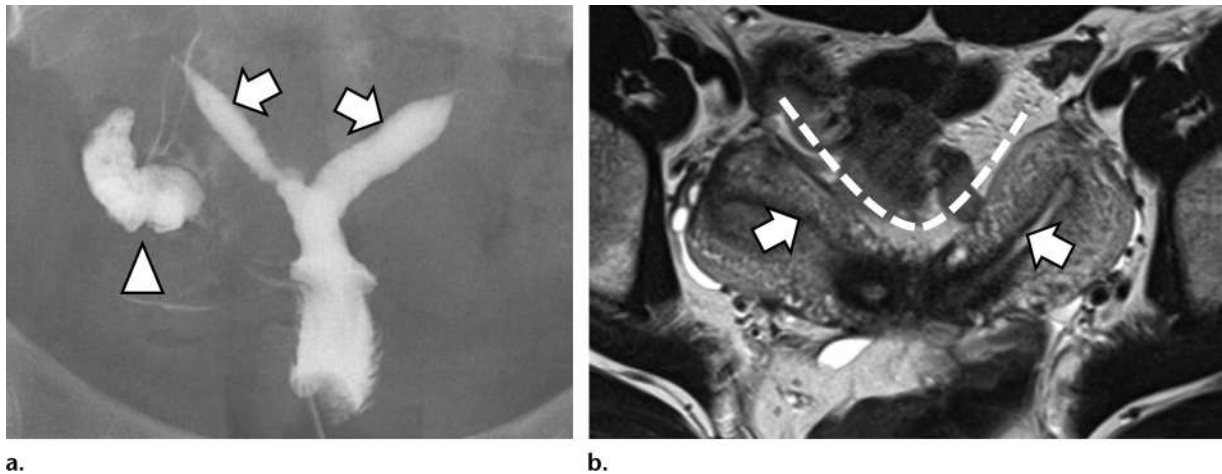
Bicornuate uterus in a 38-year-old woman. (a) HSG image shows a divided endometrial cavity (arrows). It is not possible to differentiate between bicornuate uterus and septate uterus on the basis of HSG images alone, as they do not provide information about the fundal contour. Note the right hydrosalpinx (arrowhead). (b) Axial T2-weighted MR image shows the divided nature of the external myometrial contour (dashed line), confirming the diagnosis of bicornuate uterus. Arrows = divided uterine body and cavity.
